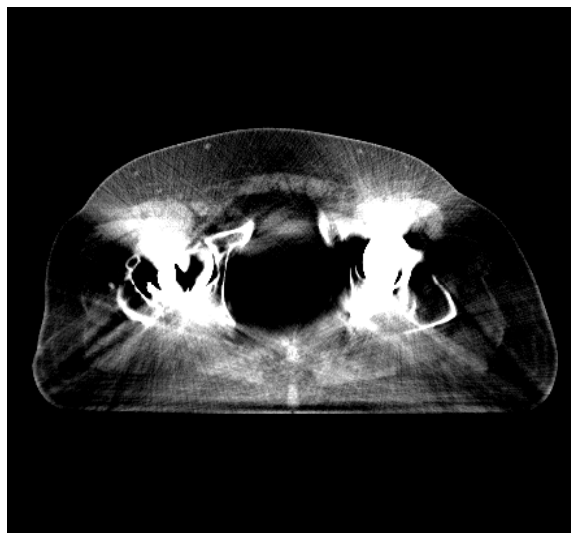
CT image of pelvis of a prostate patient with bilateral hip prosthesis. Window at 400 HU, level at 50 HU.
